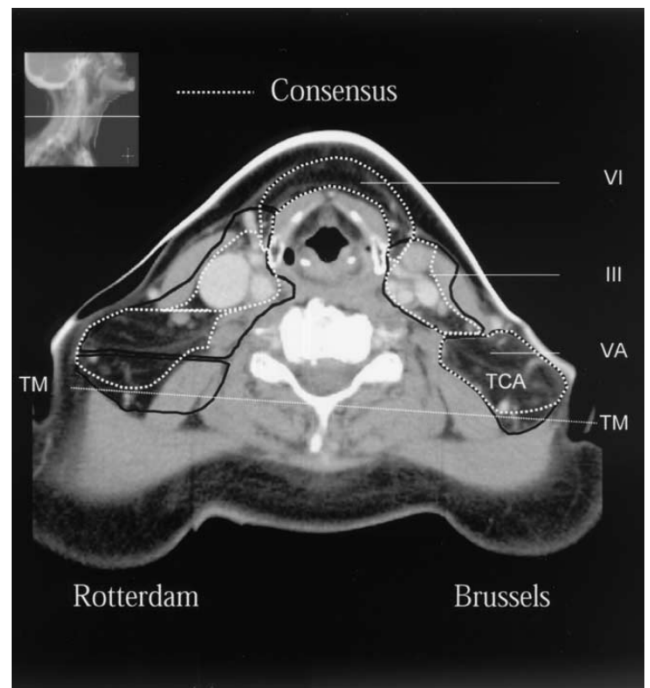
Axial CT slice, taken in region of mid-neck (level of cricoid) with nodal Levels III, V, and VI (solid black lines), contoured according to “simplified” Rotterdam (right neck) (2) and Brussels (left neck) (3) delineation protocols. Stipulated white lines (both necks) demarcate contours of same levels and sublevels when defined by Rotterdam/Brussels consensus proposal (see also Fig. 6). Virtual horizontal line between anteromedial heads of trapezius muscles (TM) demarcates posterior boundary of Level VB (see text for details).
